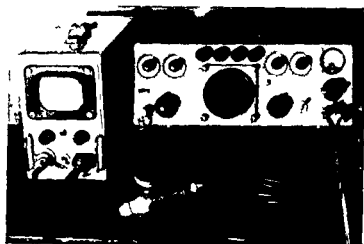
Ultrasonic diagnosing apparatus (right) and its monitor (left)
